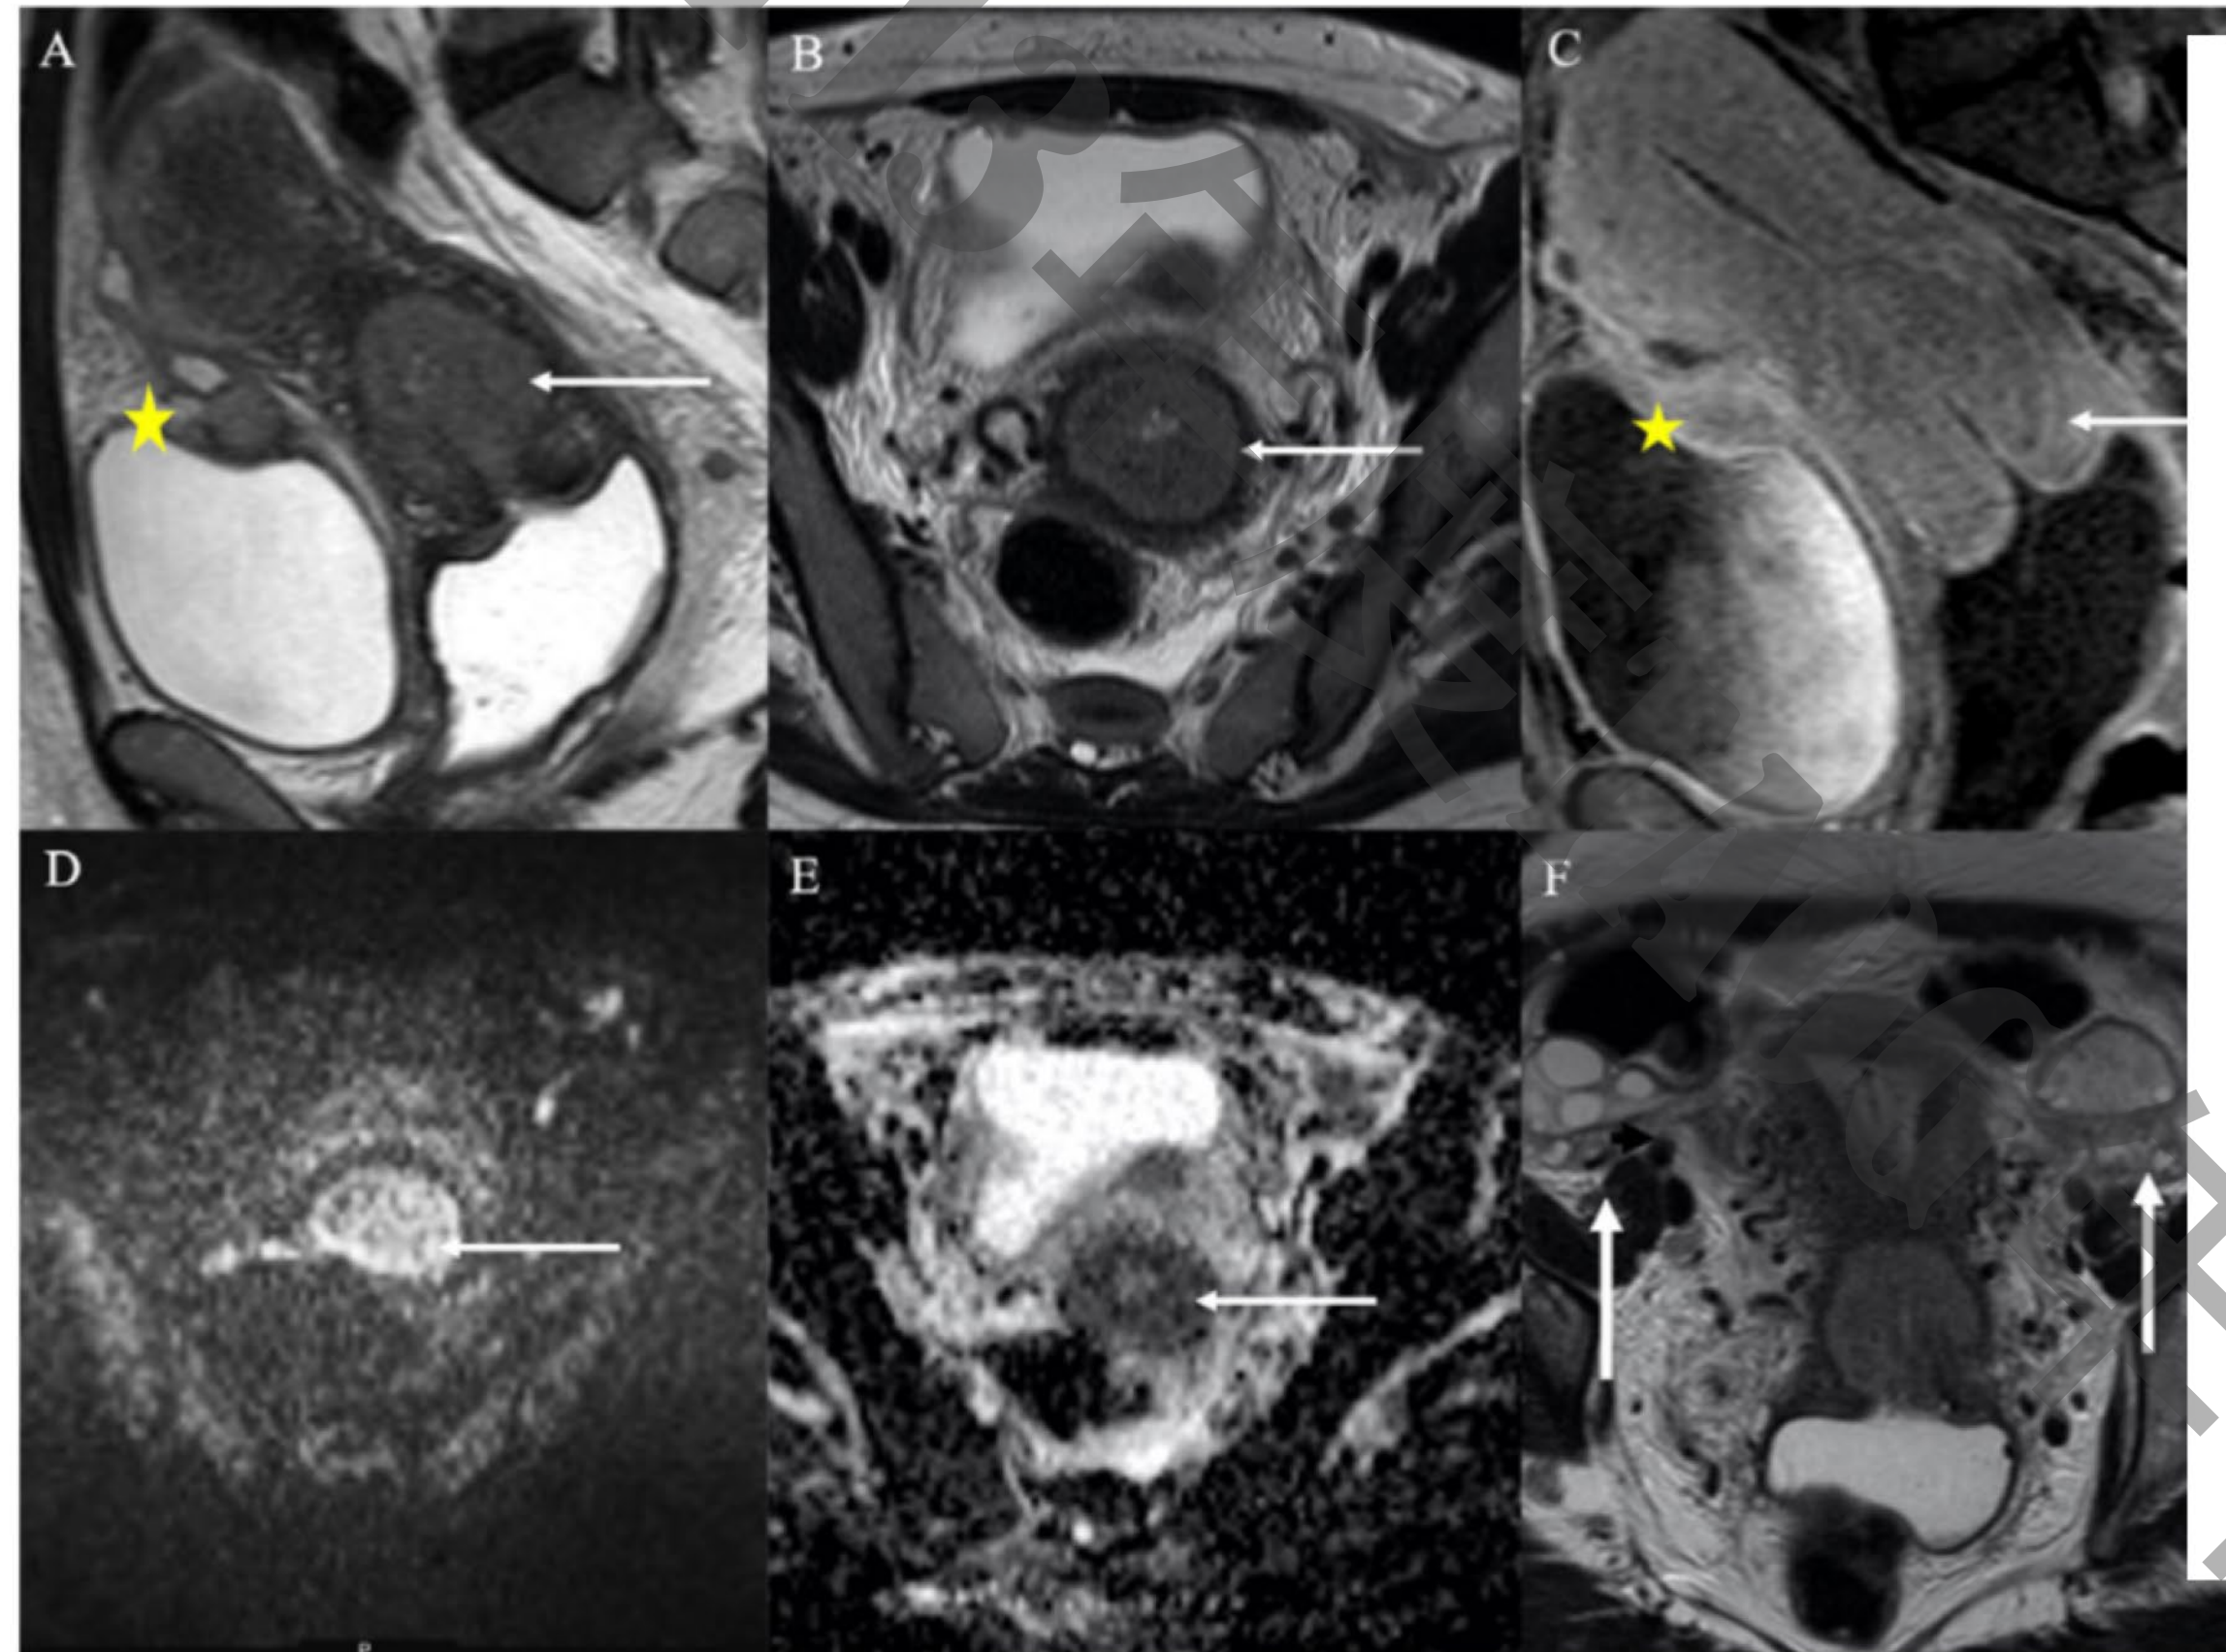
Pelvic magnetic resonance imaging (MRI) with and without gadolinium at diagnosis for initial characterization and staging of the cervical mass. (A) Sagittal T2-weighted. (B) Axial T2-weighted. (C) Axial T1-gadolinium. (D) Diffusion-weighted images (DWI) B value 1000 mm³/s. (E) Attenuation diffusion coefficient (ADC). (F) Axial T2-weighted.
